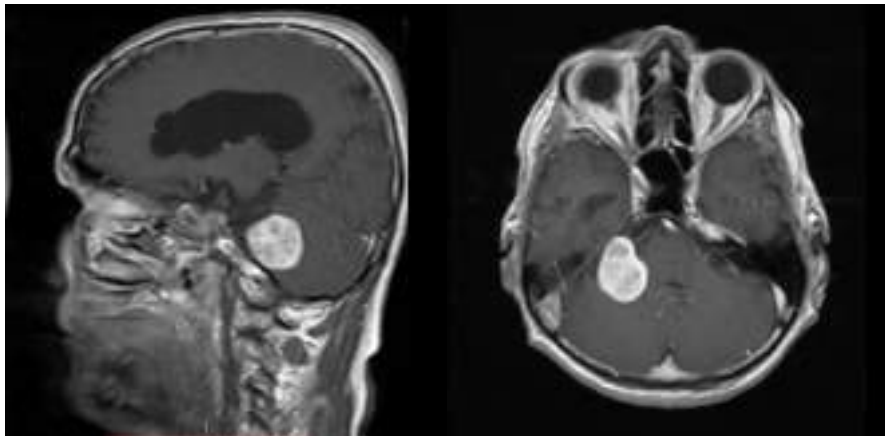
Preoperative MRI showing an intracranial lesion in the posterior fossa. The patient underwent neurosurgical intervention (Figure 2). At the ENT follow-up, he remained asymptomatic.
